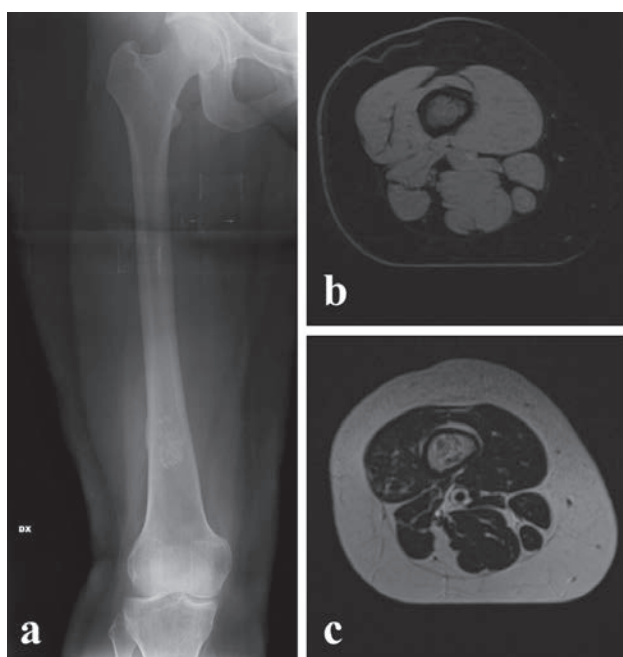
(a) Plain radiograph of the femur reveals an enchondroma with typical appearance of "stippled" calcification in center of bone; (b) Axial T1-weighted MRI demonstrates irregular low signal intensities within the lesion (c) axial T2-weighted MRI shows the sharply defined lobulated margins and characteristic "rings" of chondroid matrix
